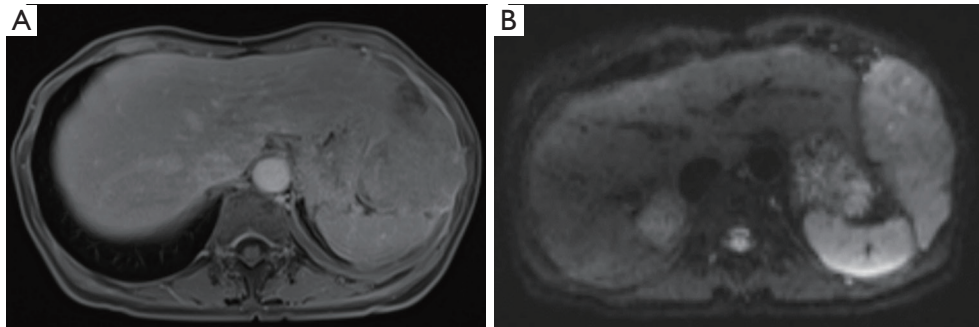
The different roles of T1-weighted and diffusion-weighted magnetic resonance imaging in MPM. (A) Axial T1-weighted MRI showing soft tissue infiltration of the MPM; (B) diffusion-weighted MR imaging (DWI) demonstrating excellent differentiation of malignant pleural disease (white lighted area) from benign pleural alterations.
